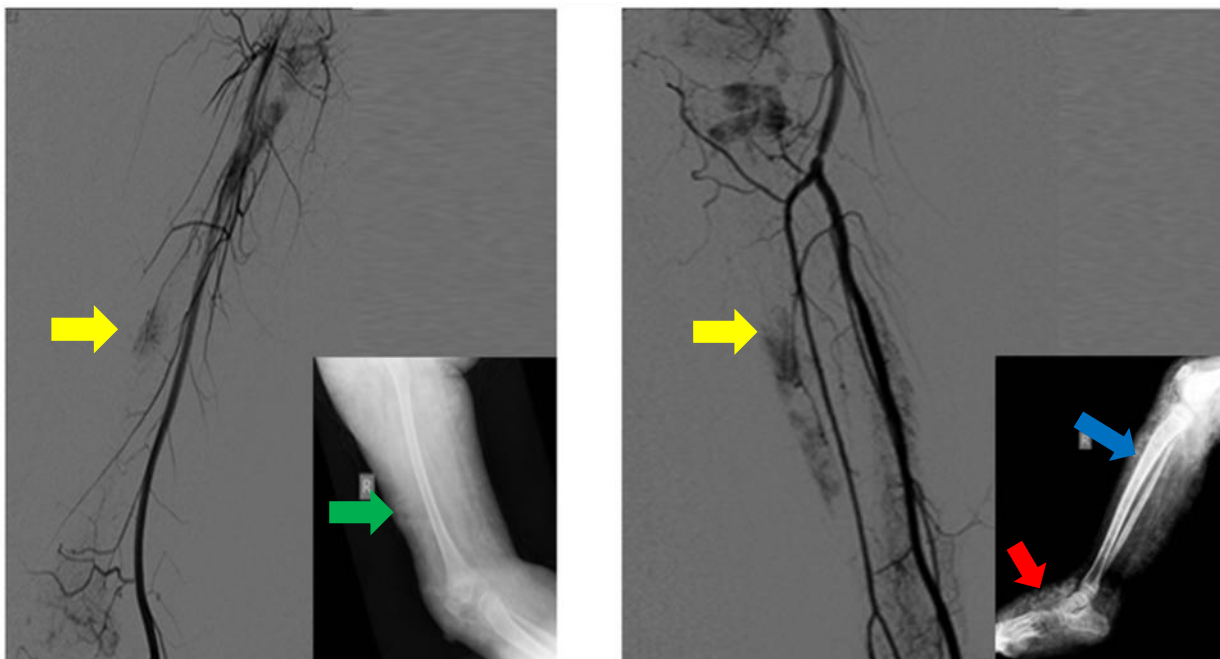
Conventional angiogram of the right thigh. (A-thigh, B-leg) There are multifocal capillary and venous malformations (yellow arrows). (Inset- corresponding lateral view radiographs)(A) Soft tissue swelling of the thigh (green arrow) and heterogeneous densities over soft tissue of the foot relating to underlying crusted lesions (red arrow). Increased cortical bone density is also present right tibia and fibula (blue arrow).
